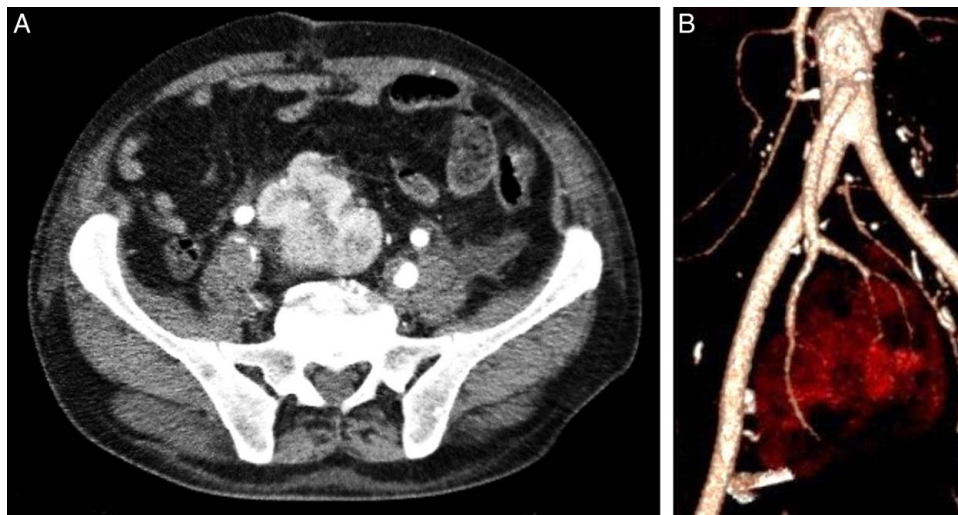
(A) Postoperative high-resolution Multi-Slice Computed Tomography Angiography (MS-CTA) image with an axial view two weeks after surgery. It shows the ectopic pelvic kidney after implanting the synthetic anastomotic graft that connects it to the synthetic abdominal aortic graft. (B) Postoperative high-resolution MS-CTA image with three-dimensional reconstruction two weeks after surgery. It demonstrates the patency of the synthetic grafts and the adequate blood supply and perfusion of the ectopic pelvic kidney.
